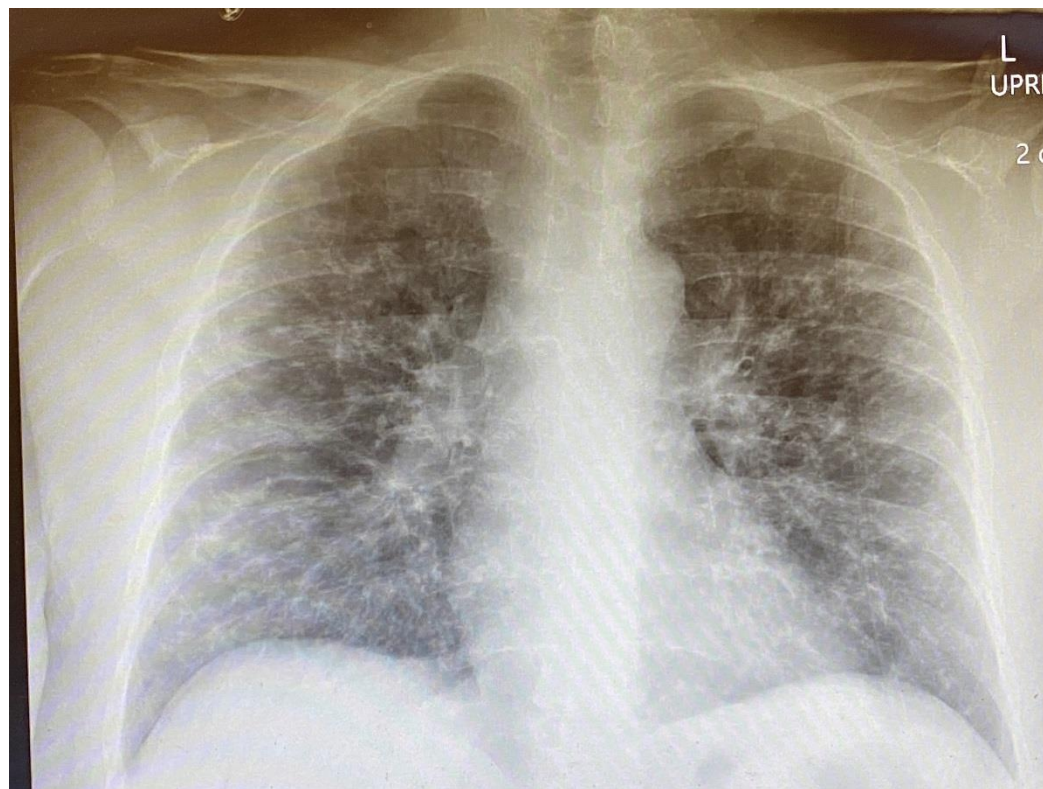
Day #17, chest x-ray with improving bilateral infiltrates.
